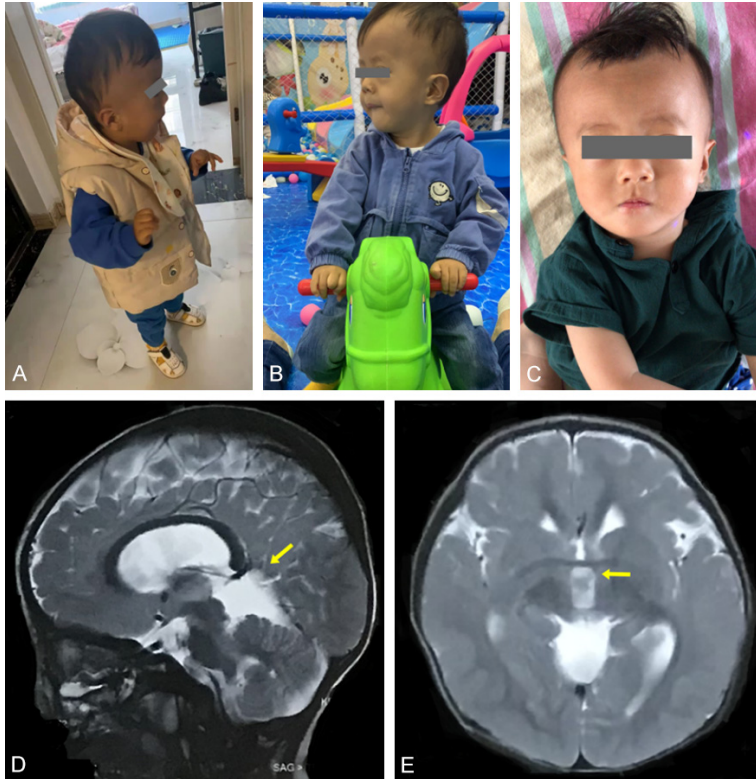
The case clinical presentation. (A-C) The appearance showed a predominant forehead, periorbital fullness, declivitouslateral canthus, low-set special ears, and malar hypoplasia. (D, E) MRI images indicated widened bilateral ventricles and the third ventricle, slightly enlarged superior cerebellar cistern and greater occipital cistern, and slightly deepened regional sulci.
